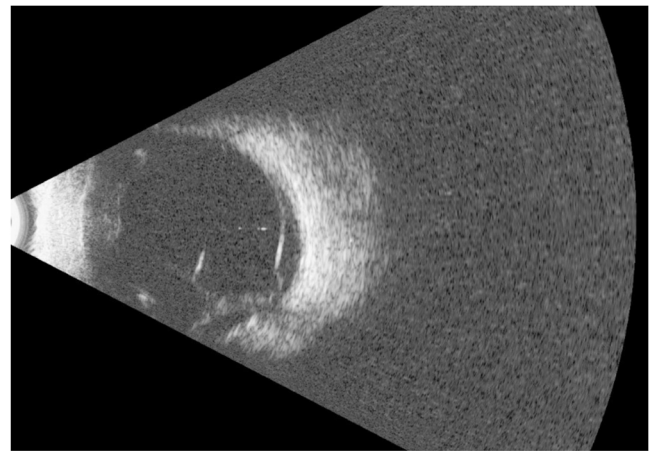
B-scan ultrasound image of right eye, demonstrating retinal detachment.
